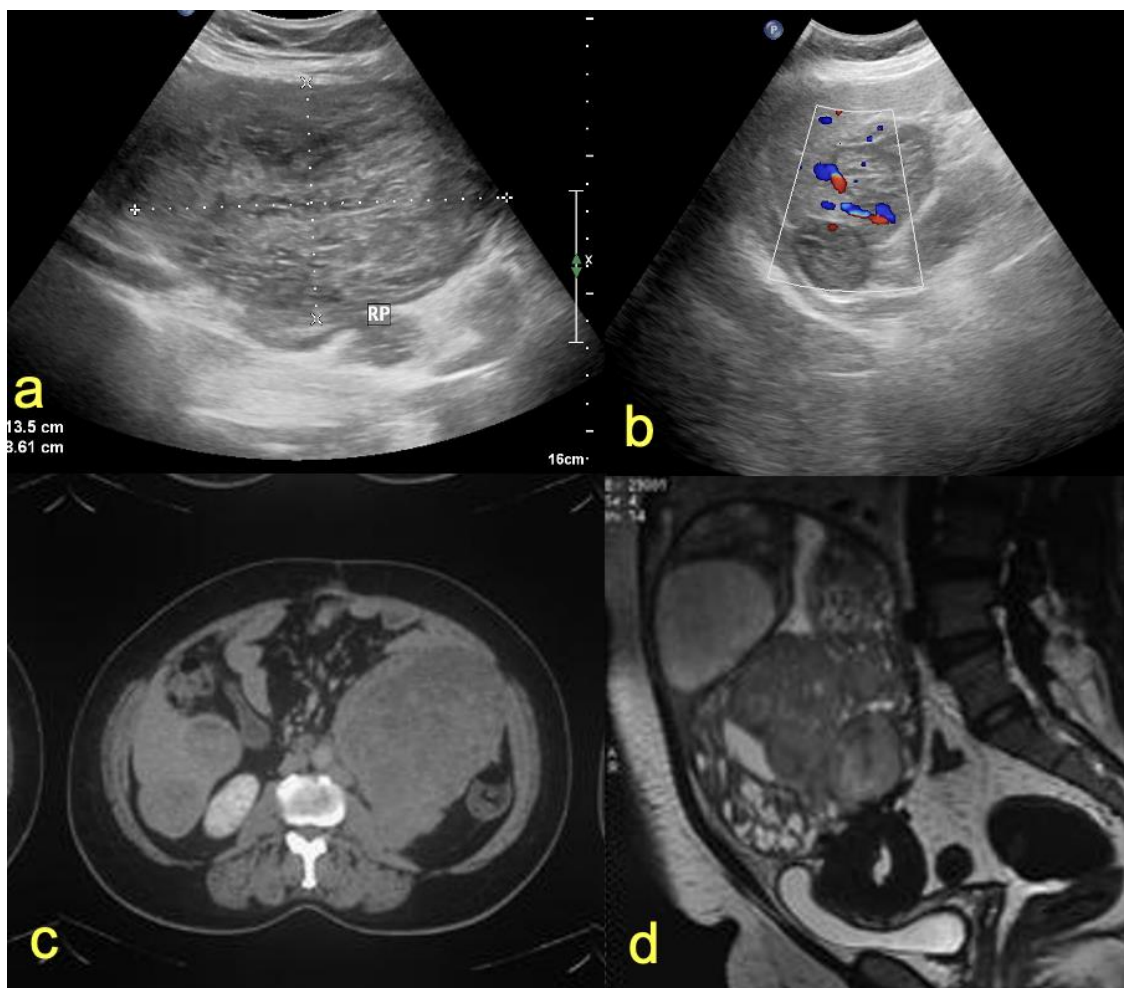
US abdomen shows retroperitoneal and hepatic masses. 1c. CECT abdomen shows a mass in the left anterior pararenal space and multiple hepatic masses. 1d. Previous pelvic MRI (8 years back) showed similar morphology right ovarian mass.
